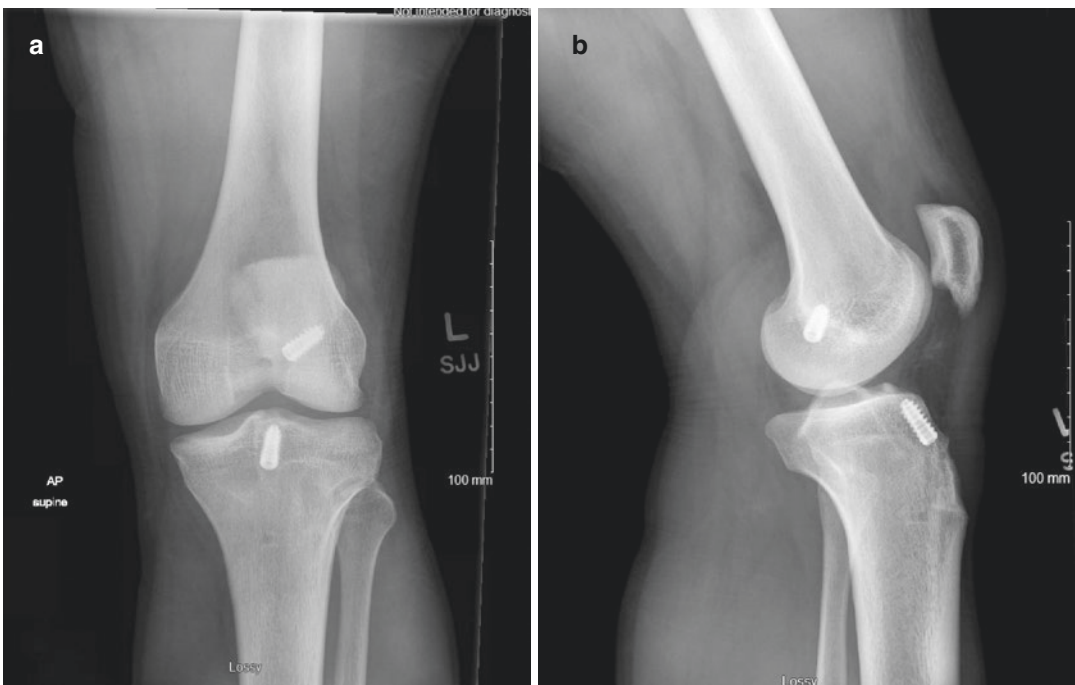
AP (a) and lateral (b) preoperative radiographs of the left knee prior to ACL revision procedure
